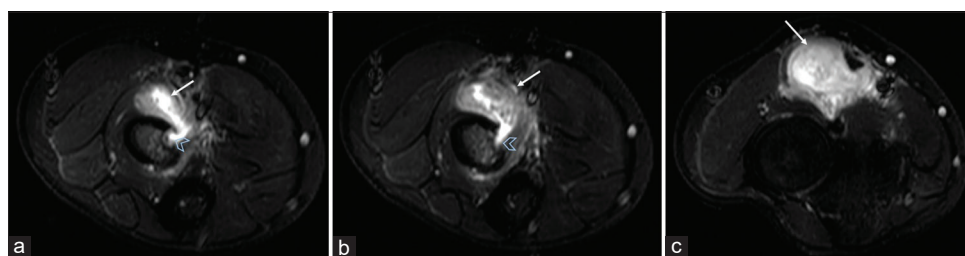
(a-c): Axial STIR MR images of the right elbow showing a heterogeneous mass with high signal intensity (white arrow) in the anterior compartment, infiltrating the radius (open blue arrowhead)
